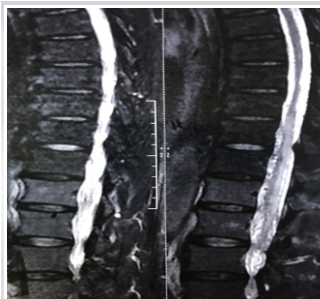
MRI showing lower thoracic cord edema with significant flow voids
